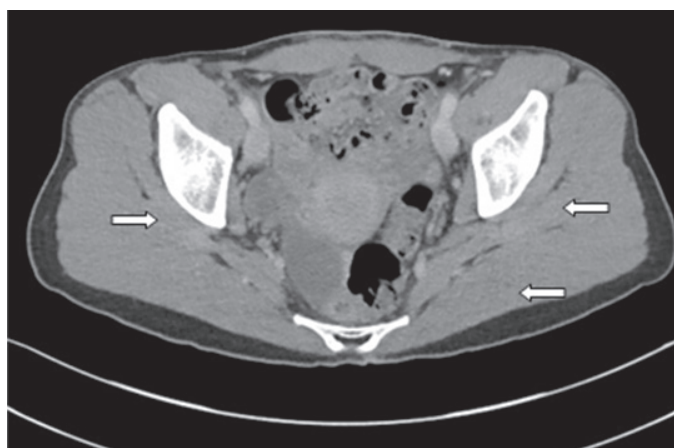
Axial computed tomography imaging of patient, six months into treatment. Lack of ovarian masses and free fluid in pelvis.
